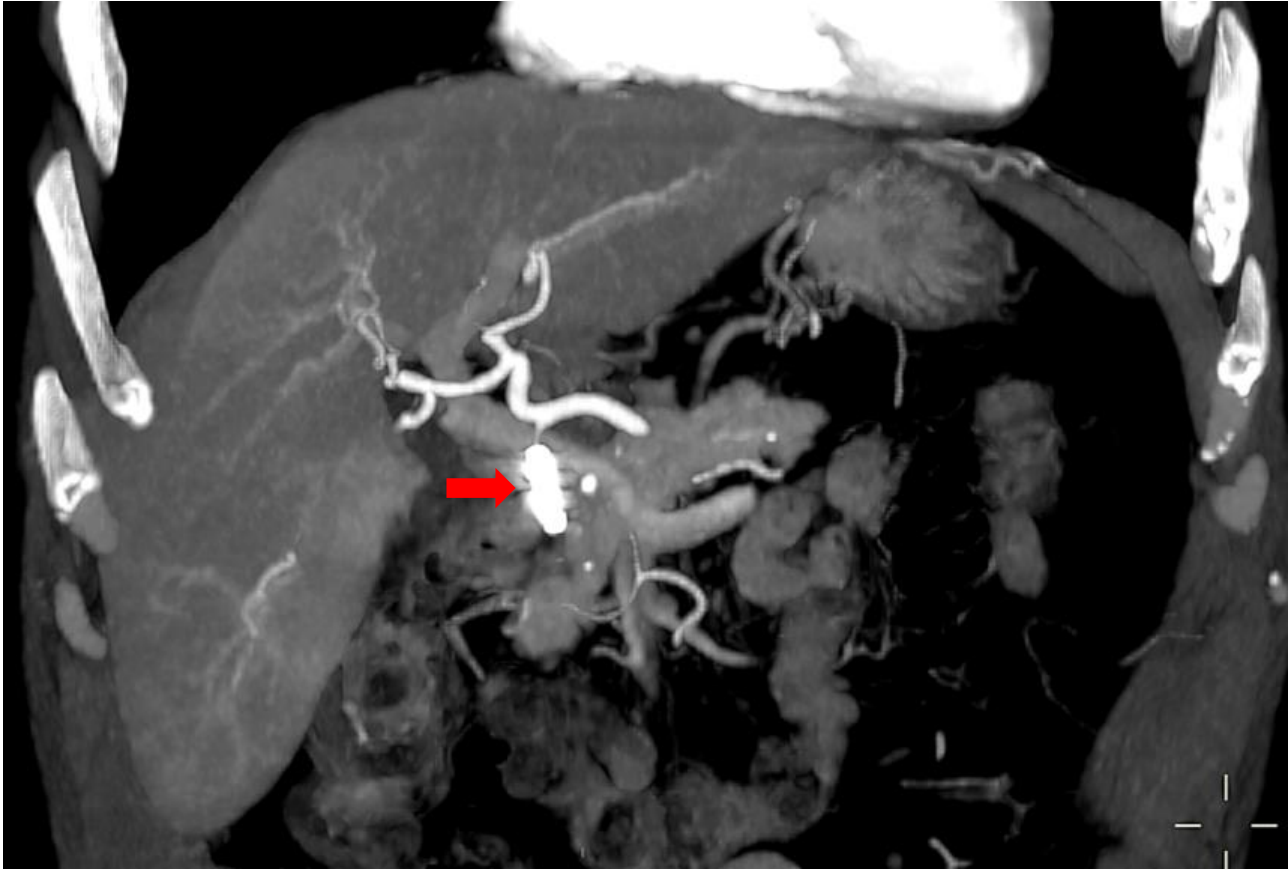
Abdominal CT showing GDA pseudoaneurysm.
